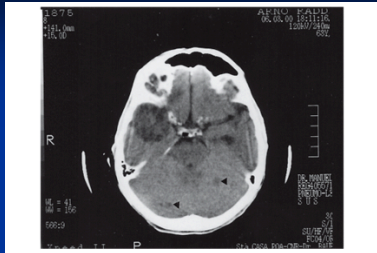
Contrast-enhanced axial cranial computed tomographic scan reveals cryptococcoma within the right temporal lobe and multiple nodules (arrows) through the brain parenchyma.
